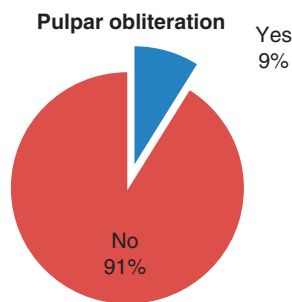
Radiographic pulpar obliteration.
